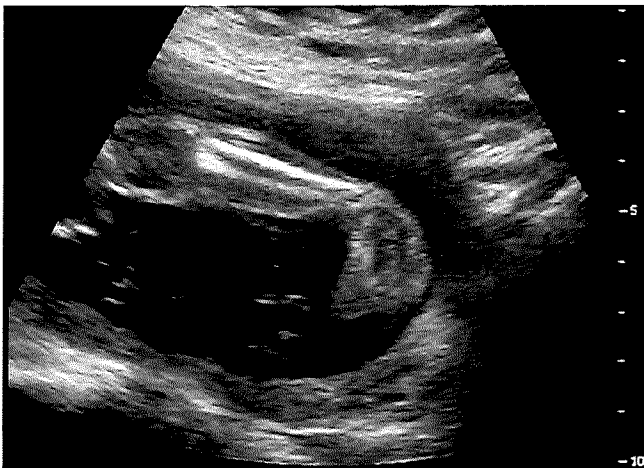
The clubfoot is diagnosed by ultrasound *in utero* when there is persistent medial deviation and equinus of the foot relative to the tibia. (From the private collection of James R. Kasser, MD.)
